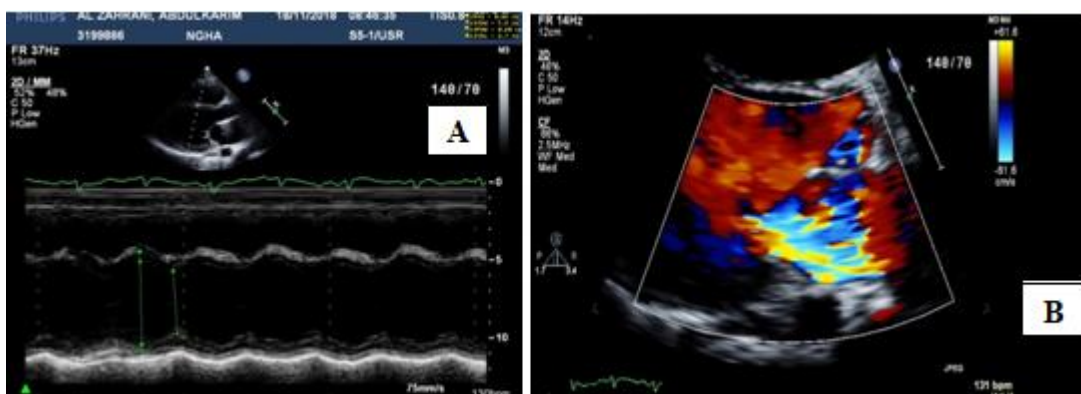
(A) and (B) Echocardiography with Moderate MR and EF of 35-40%. (C) Post treatment by 3 days with EF improvement up to 52.6 %
